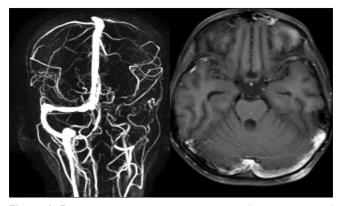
Repeat magnetic resonance imaging showing near total recanalization of the right transverse sinus. Few collateral vessels are seen along the surface of the sinus
